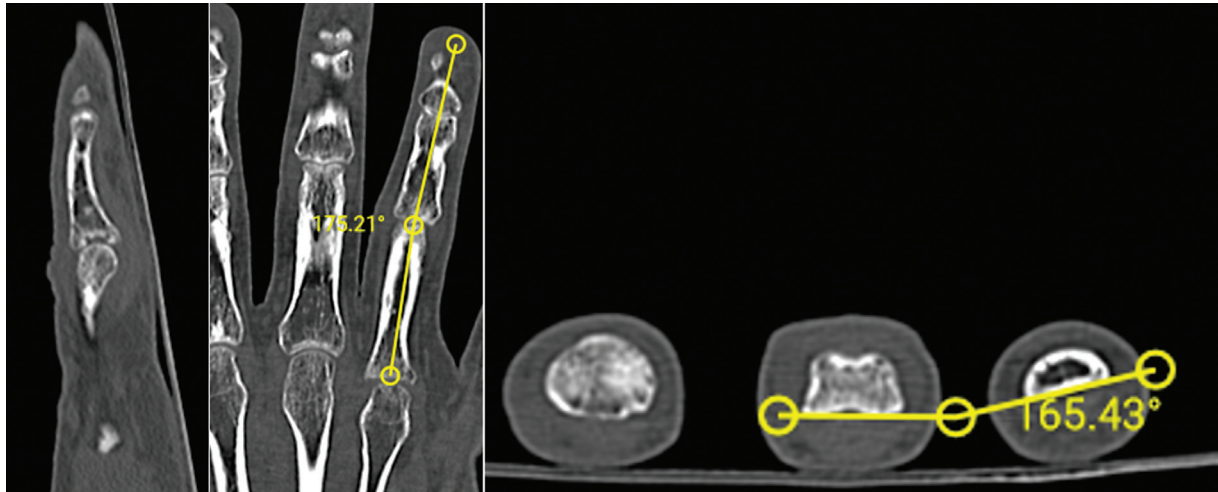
Computed tomography scan showing and quantifying the angular and rotational deformities caused by the intra-articular fracture.
